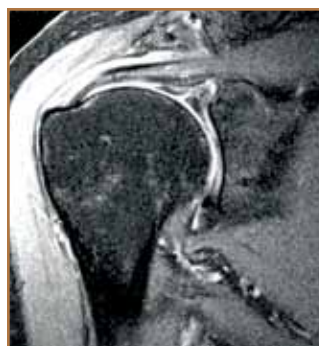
Coronal, fat-suppressed magnetic resonance imaging of right shoulder of same patient (51-year-old woman) shows superior labral anterior-posterior (SLAP) lesion.
